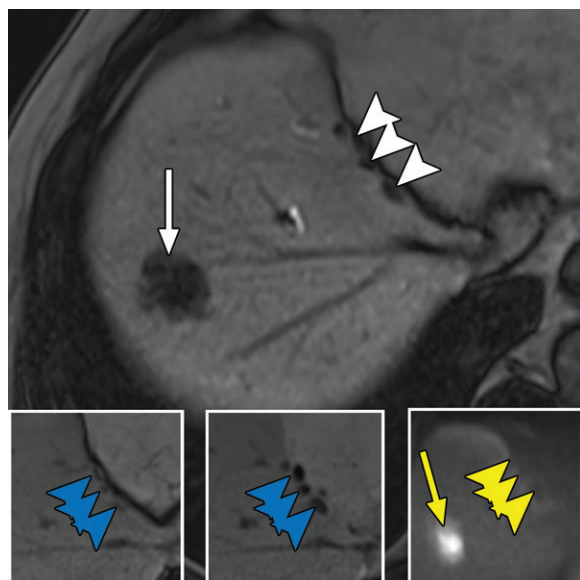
Susceptibility artifacts from surgical clips mimicking subcapsular hepatic metastases in a 62-year-old man with metastatic colon cancer after left hemihepatectomy. Axial T1-weighted HBP MR image shows a segment VII hypointense hepatic metastasis (white arrow) and several hypointense foci along the surface of the right hemiliver (white arrowheads), which might be mistaken for metastases along the resection margin. However, there is no corresponding diffusion restriction (right inset, yellow arrowheads), unlike the hyperintense metastasis (yellow arrow). Blooming artifact (blue arrowheads) is depicted with accentuation of hypointensity on the longer-TE in-phase image (middle inset) compared with on the shorter-TE opposed-phase image (left inset), confirming susceptibility artifact from clips as the source of these imaging findings.
